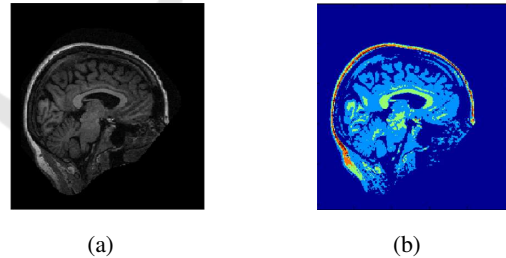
Classification using PNN: (a) An input sagittal brain MRI. (b) Resulting cluster map generated by PNN.
